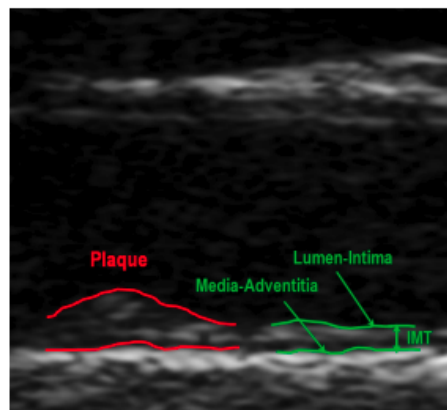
Common Carotid artery ultrasound. Red lines show the presence of an atherosclerosis plaque and the green lines show the IMT measurement.
